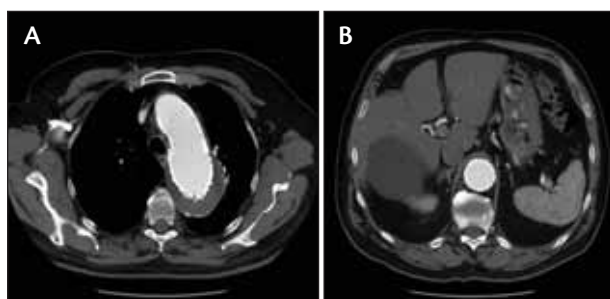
A CT scan at 3 months shows no evidence of an endoleak with sac shrinkage (A). A CT scan at 3 months shows an excellent result at the distal landing zone with no endoleak (B).
